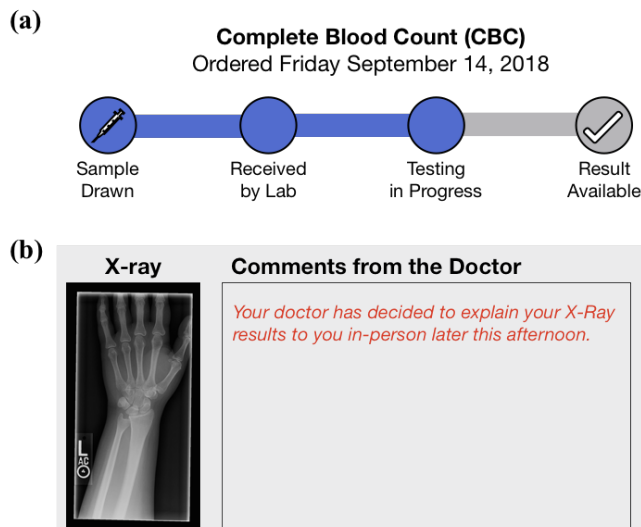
(a) Tracking the status of a blood test, from when the sample is drawn to when the result is made available in the inpatient portal. (b) An X-ray image next to a comment describing a provider’s intention to explain the results to the patient in-person before releasing them in the inpatient portal.
